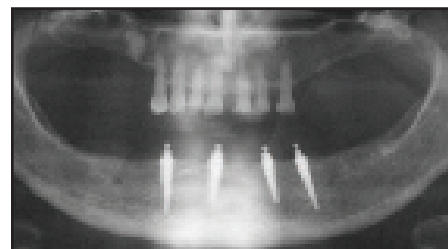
Immediate postoperative panoramic radiograph
